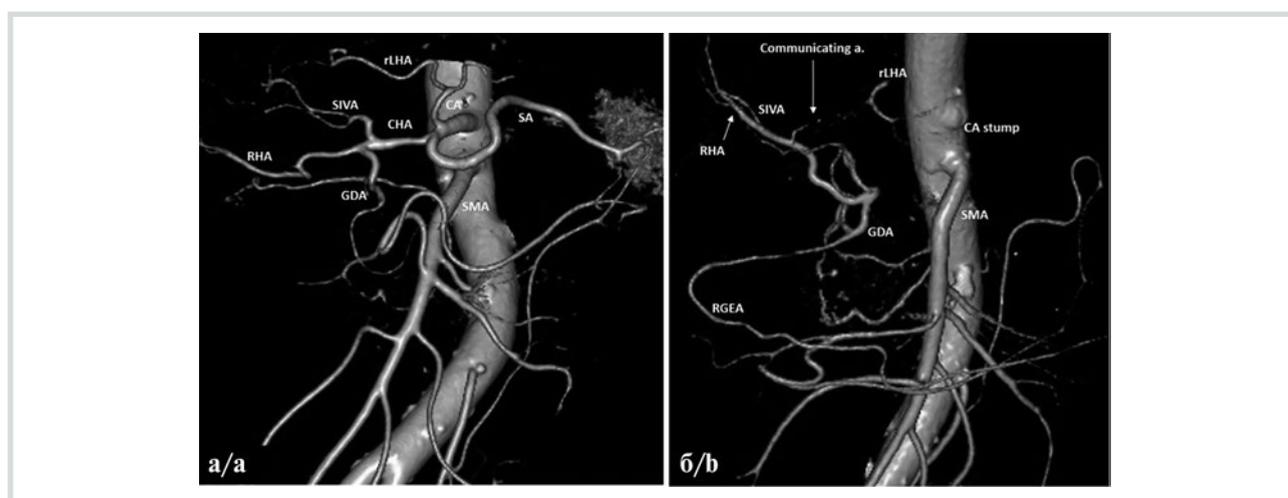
Ductal adenocarcinoma of the pancreatic body in a 59-year-old male. 3D CT angiography.
